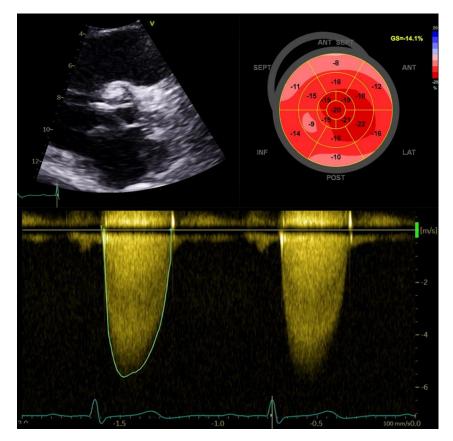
High risk echocardiographic features of severe AS. Top left: Severely calcified aortic valve Top right: Impaired global longitudinal strain at -14.1% Bottom: Aortic valve Vmax >5.5 m/s
